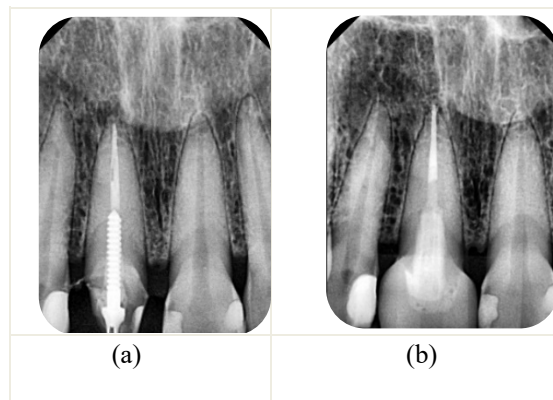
Radiographic appearance of 11 (a) Pre-op periapical radiograph prior to retreatment (b) Eight-month follow up radiograph showing satisfactory outcome after completion endodontic retreatment and definitive restoration.
